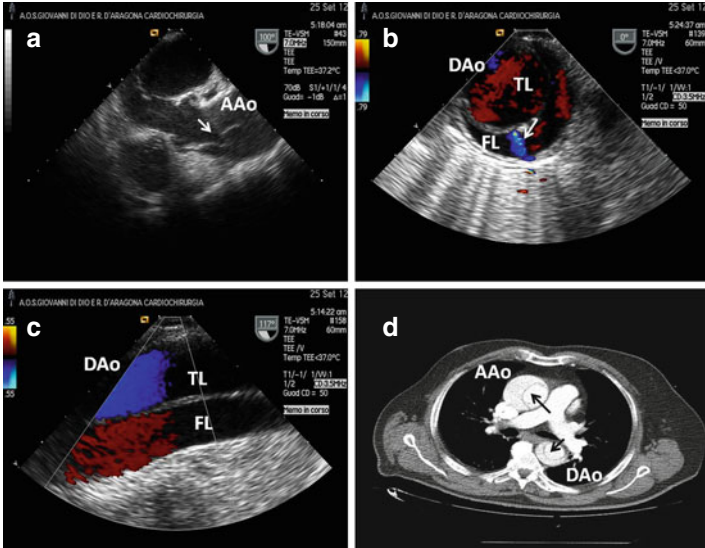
Chronic Stanford A aortic dissection in 68 years old man with history of hypertension and chest pain occurred 2 months before hospital admission. (a) Transesophageal echocardiography (TEE) in long axis view demonstrating intimal flap (see *arrow*) in ascending aorta (AAo). (b) and (c) TEE in short and long axis view respectively of the descending aorta (DAo) showing anterior true lumen (TL) and posterior false lumen (FL); note a distal small intimal tear (b, see *arrow*). (d) Computed tomography of the aorta: intimal flap (see *black arrows*) in both ascending and descending tract can be appreciated
